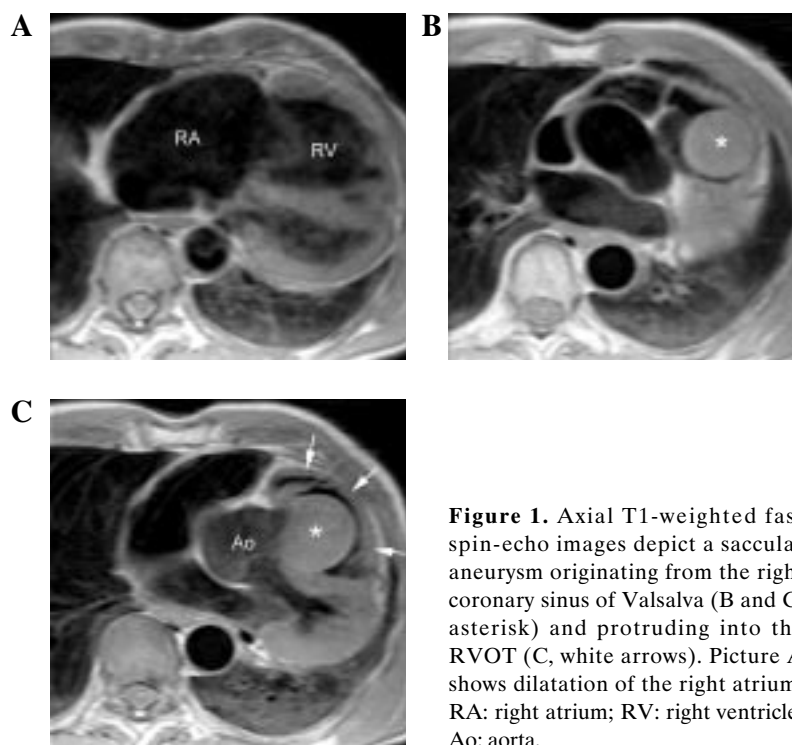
Axial T1-weighted fast spin-echo images depict a saccular aneurysm originating from the right coronary sinus of Valsalva (B and C, asterisk) and protruding into the RVOT (C, white arrows). Picture A shows dilatation of the right atrium. RA: right atrium; RV: right ventricle, Ao: aorta.
